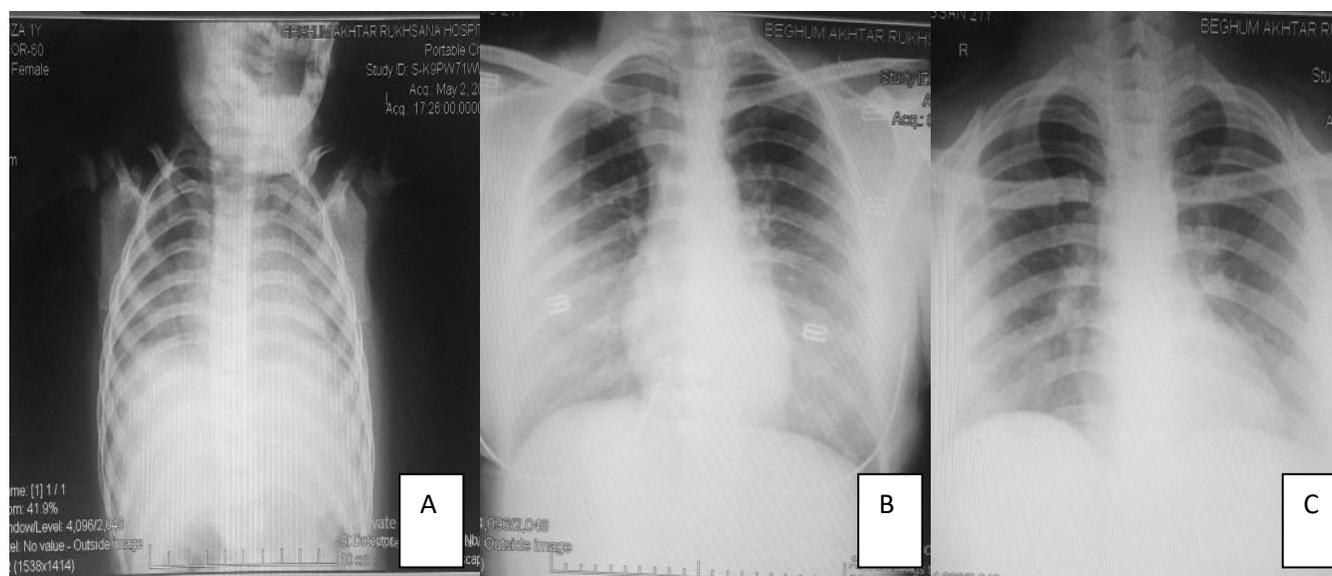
Chest X-Ray (A/P) of child (A), father (B) and mother(C).
